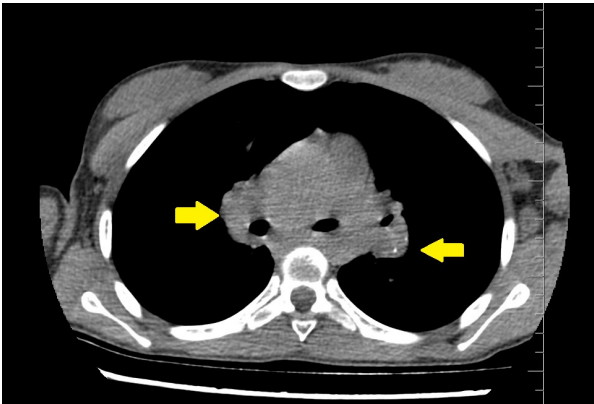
Hilar lymph node enlargement- Non enhanced chest CT. Multiple bilateral hilar lymphadenopathies and left-sided calcifications, consistent with tuberculosis on non-contrast CT scan.
